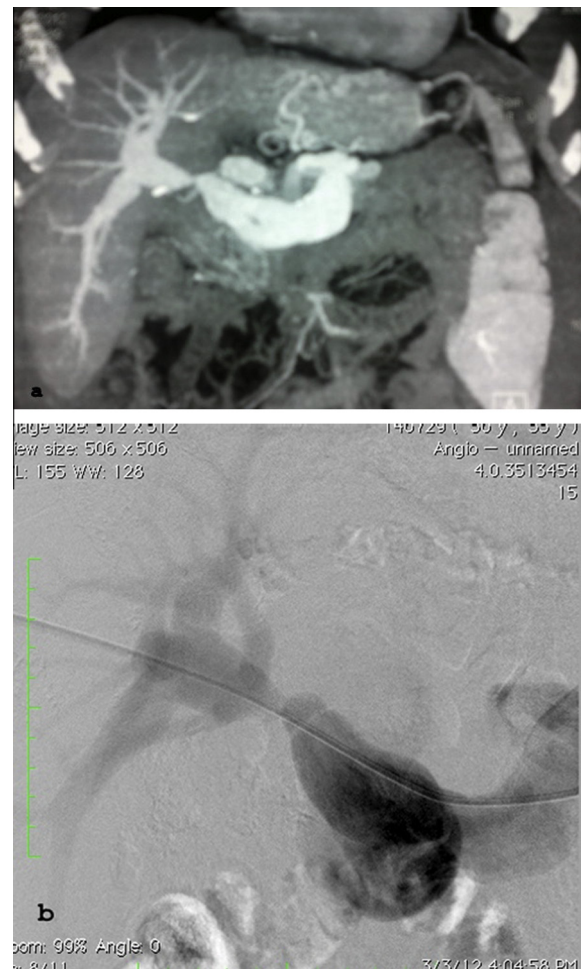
Forty year old female recipient 1-month post LDLT, with clinical signs of portal hypertension. (a) Coronal CT angiography MIP image showing tight stricture at the portal vein anastomosis (b) Percutaneous transhepatic portography showed dilated splenic and portal vein with tight anastomotic stricture and size mismatch between the recipient and donor portal veins.
